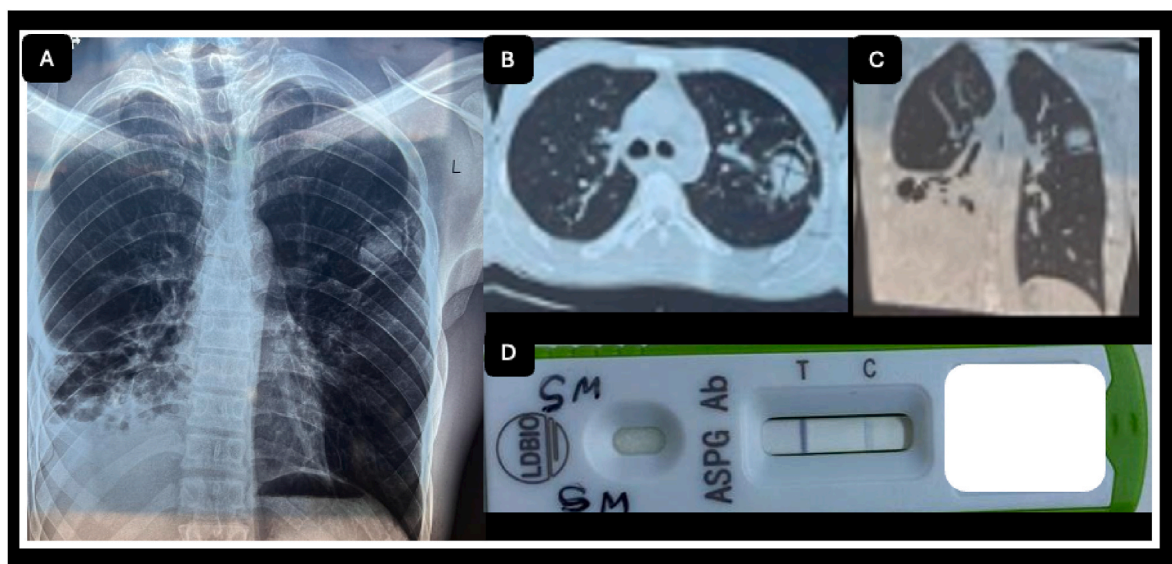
Chest x-ray showing lung fibrosis and bronchiectasis in the right lung, along with an intracavitary fungal ball in the left upper zone (1A), a chest CT showing intra-cavitary fungal ball in the left upper lung zone, with fibrosis and bronchiectasis in the right lower lung zone (1B & C), and a positive LD Bio *Aspergillus* IgG-IgM lateral flow assay (1D).
